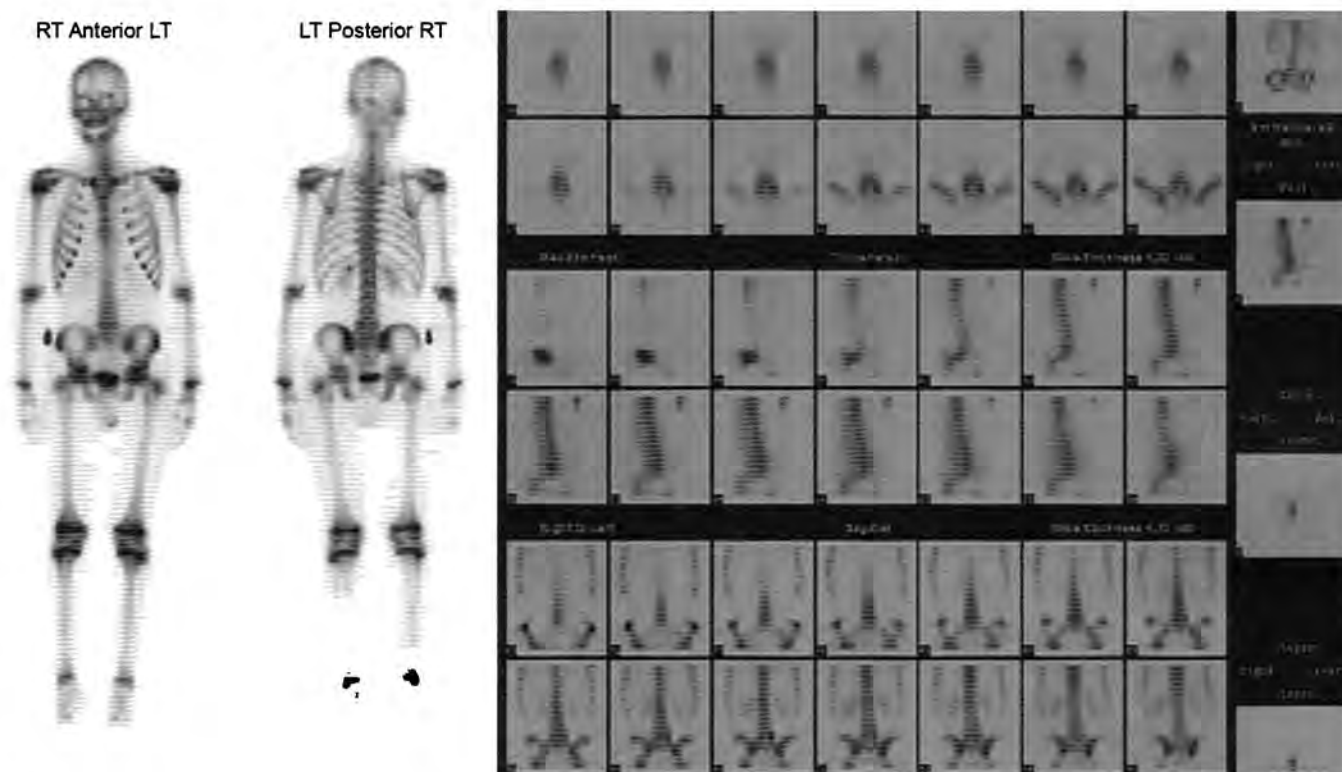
Whole body ^{99m}Tc -Methyl diphosphonate (MDP) images (A) demonstrate increased radiotracer uptake in the right and left L5 posterior element, greater on the left side. SPECT images of the lumbar spine (B) localizes this uptake in both L5 pars interarticularis, greater on the left side. The findings are compatible with left L5 spondylolysis and reactive uptake in the right L5 pars interarticularis.
